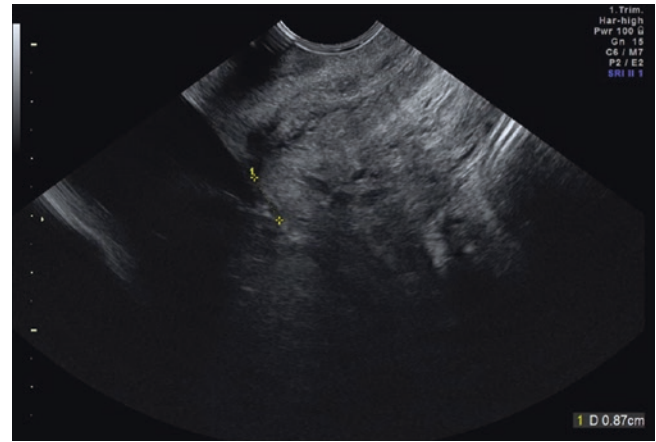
Lower placental edge – internal cervical os distance measuring <20 mm at transvaginal ultrasound
